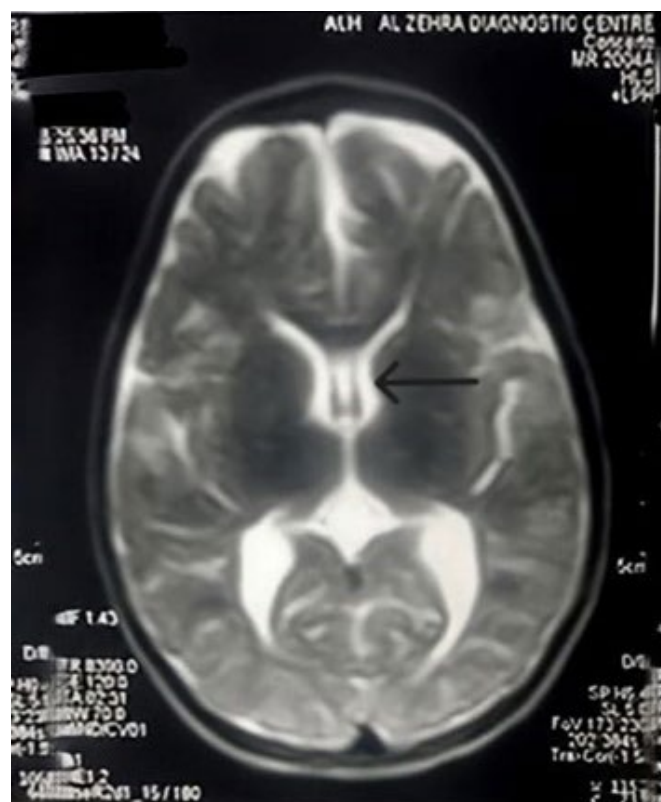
T2 Weighted MRI of the patient showing cavum septum pellucidum cyst (arrow).
